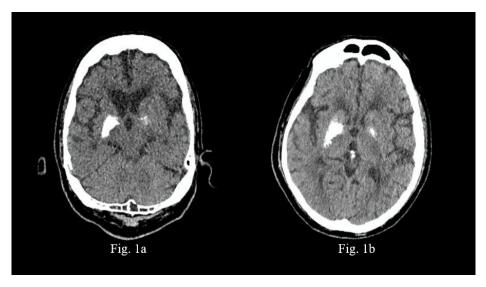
1a. Non-contrast CT scan of the brain showing calcifications in the basal ganglia, without further comments at the patient's care center. 1b. Non-contrast CT scan of the brain showing confluent calcifications in the basal ganglia, predominantly on the right side, which had already been observed in a previous study.
